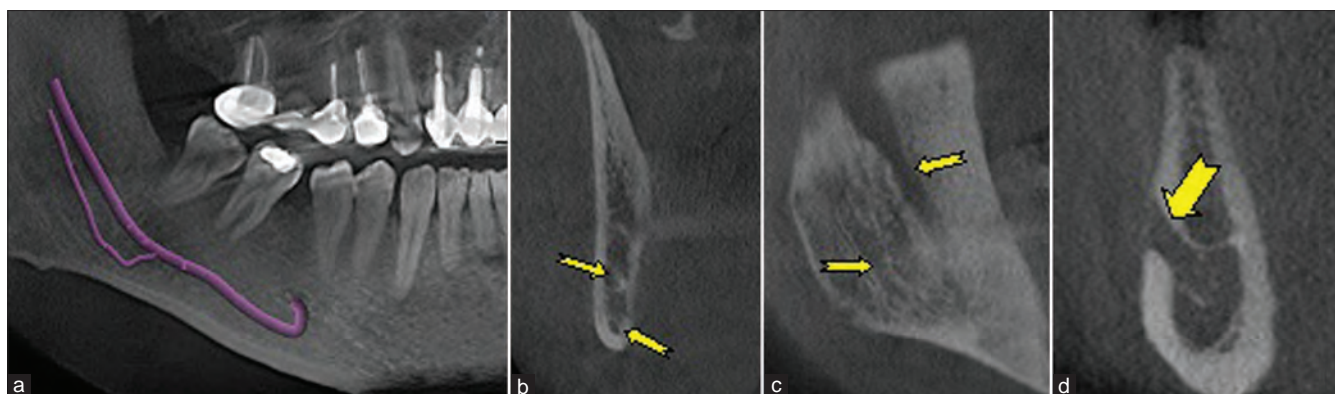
CBCT images of right mandibular canal, a: panoramic view, b: coronal view, c: sagittal-oblique view, d: cross-sectional view. In the right side, the mandibular canal ended to two mandibular foramens and only one mental foramen
